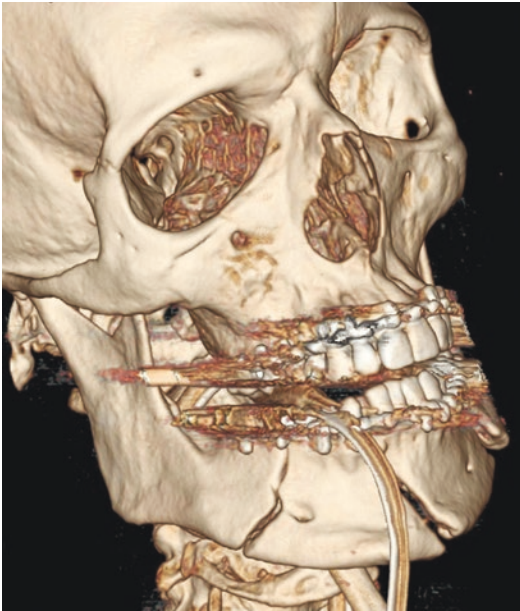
3D CT (left oblique view) demonstrating the displaced left body and symphyseal mandible fractures
